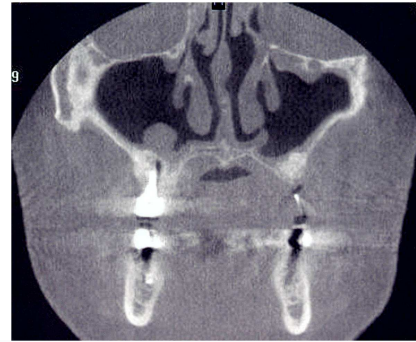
Dental CT image in the coronal plane revealed mucous pseudocyst in the left maxillary sinus.
